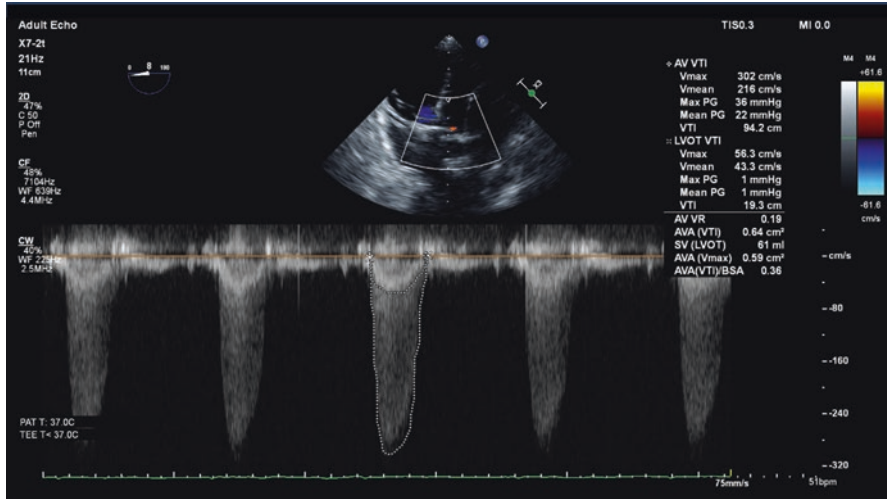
CWD through the aortic valve with a double-envelope tracing. Here, the LVOT and AV VTIs can be compared on the same cardiac ejection with the same Doppler alignment
